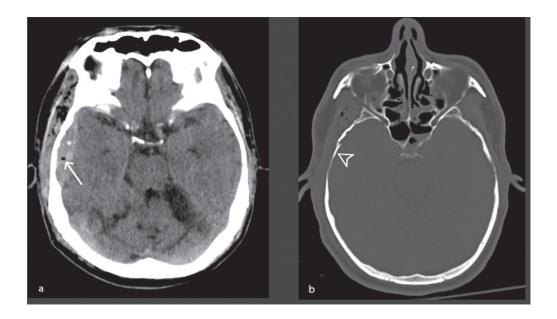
(a) Axial cranial CT scan (brain window) shows extra-axial, lens-shaped hyperdense lesion along the right temporal convexity (*), compatible with epidural hematoma, with internal pneumocephalus (arrow). Overlying soft tissue swelling and subcutaneous emphysema at the right temporal region are seen. Encephalomalacia at bilateral cerebellar hemispheres is also noted. (b) Axial cranial CT scan (bone window) shows fractures at the squamous part of the right temporal bone (arrowhead).
